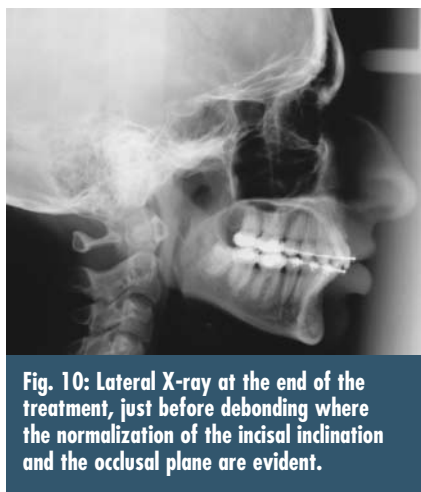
Lateral X-ray at the end of the treatment, just before debonding where the normalization of the incisal inclination and the occlusal plane are evident.
